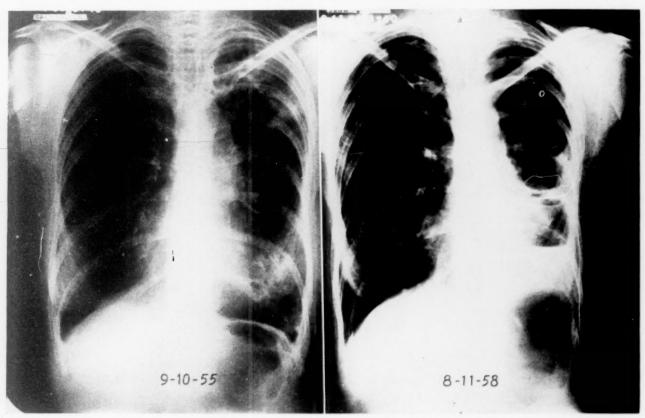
Admission and three year follow-up roentgenograms of patient L. McW. whose disease progressed and whose sputum remained consistently positive for photochromogens during three years of continuous drug therapy.
